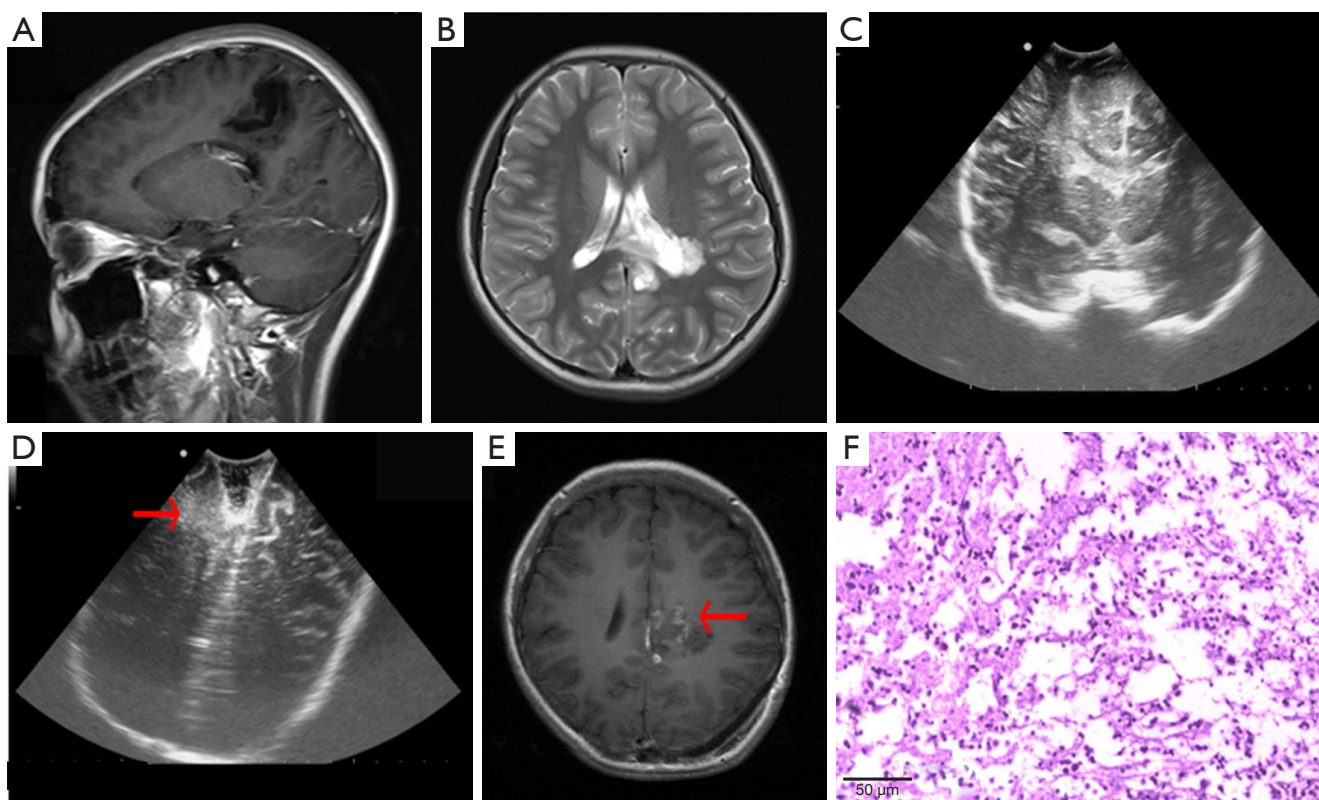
Female, 11 years old. (A,B) Preoperative MRI T1 sagittal and T2 transverse axial images. The lesion is located near the left frontoparietal midline, cingulate gyrus, and lateral ventricle, with a mass shape and long T1 and long T2 signals with clear boundaries. (C) IoUS detected a patchy uneven, slightly hyperechoic lesion at the same position with unclear boundary. (D) The residual tumor around the operation cavity was detected using postoperative ultrasound (red arrow). (E) Postoperative MRI confirmed residual lesions (red arrow) and linear enhancement at the edge of the lesions. (F) Intraoperative pathology showed floating neurons in the area of the tumor cells (HE, $\times 40$), which was consistent with DNT. MRI, magnetic resonance imaging; IoUS, intraoperative ultrasound; DNT, dysembryoplastic neuroepithelial tumor.
